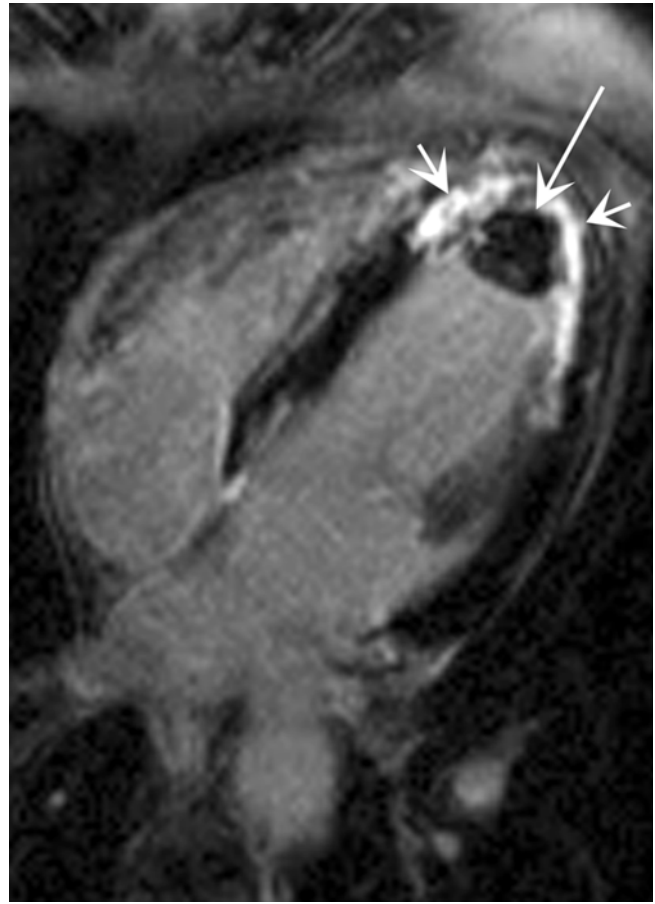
Anterior myocardial infarction in a 30-year-old man who presented with chest pain, troponin elevation, and echocardiographic abnormalities after receiving a hematopoietic stem cell transplant. Late gadolinium enhancement magnitude inversion recovery image in a four-chamber view demonstrates subendocardial enhancement in the left anterior descending coronary artery territory of distribution (*short arrows*). The mass in the left ventricle does not demonstrate enhancement, indicating an associated intraventricular thrombus (*long arrow*). The combination of a non-enhancing mass adjacent to an area of infarcted myocardium is highly suggestive of a thrombus
